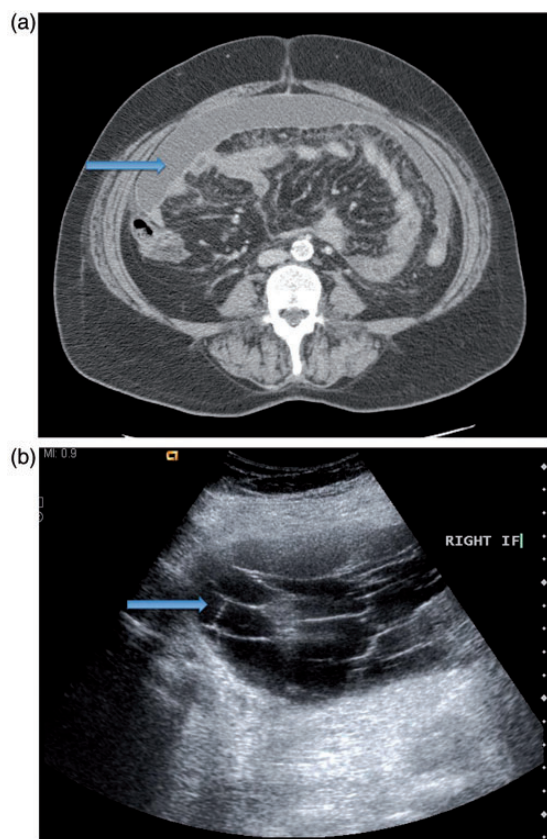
(a) Contrast-enhanced CT scan: Transverse section through the abdomen demonstrating ascites loculated beneath the abdominal wall (arrow). (b) US of the right iliac fossa (RIF) demonstrates complex ascites (arrow). Multiple septations are noted throughout the fluid suggestive of an exudate.
